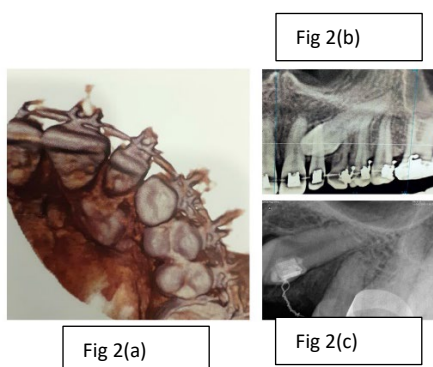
2 radiographic interpretation (a)- 3D CBCT confirms palatal position. (b) OPG (c) RVG
